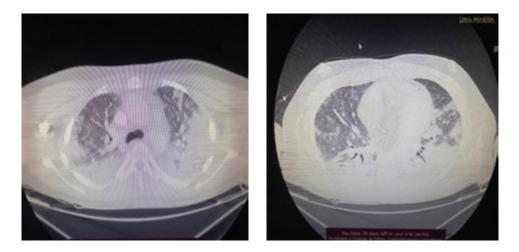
CT findings of ARDS in the patient.
